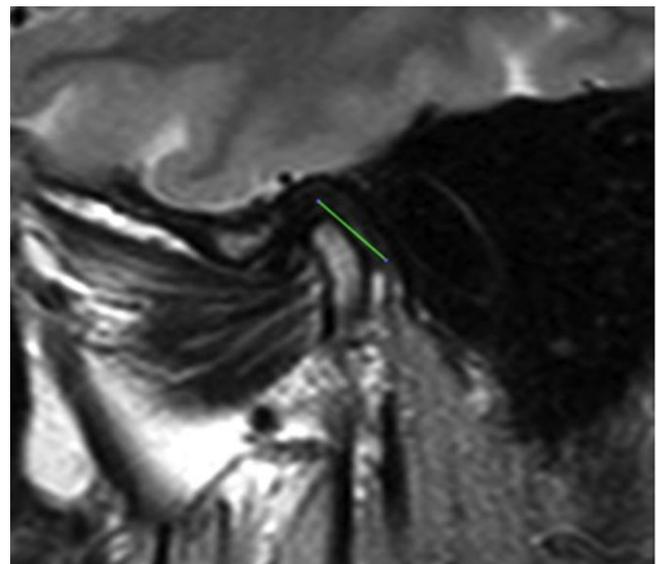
MRI: sagittal plane, T2-weighted image. Retrodiskal Zone.
